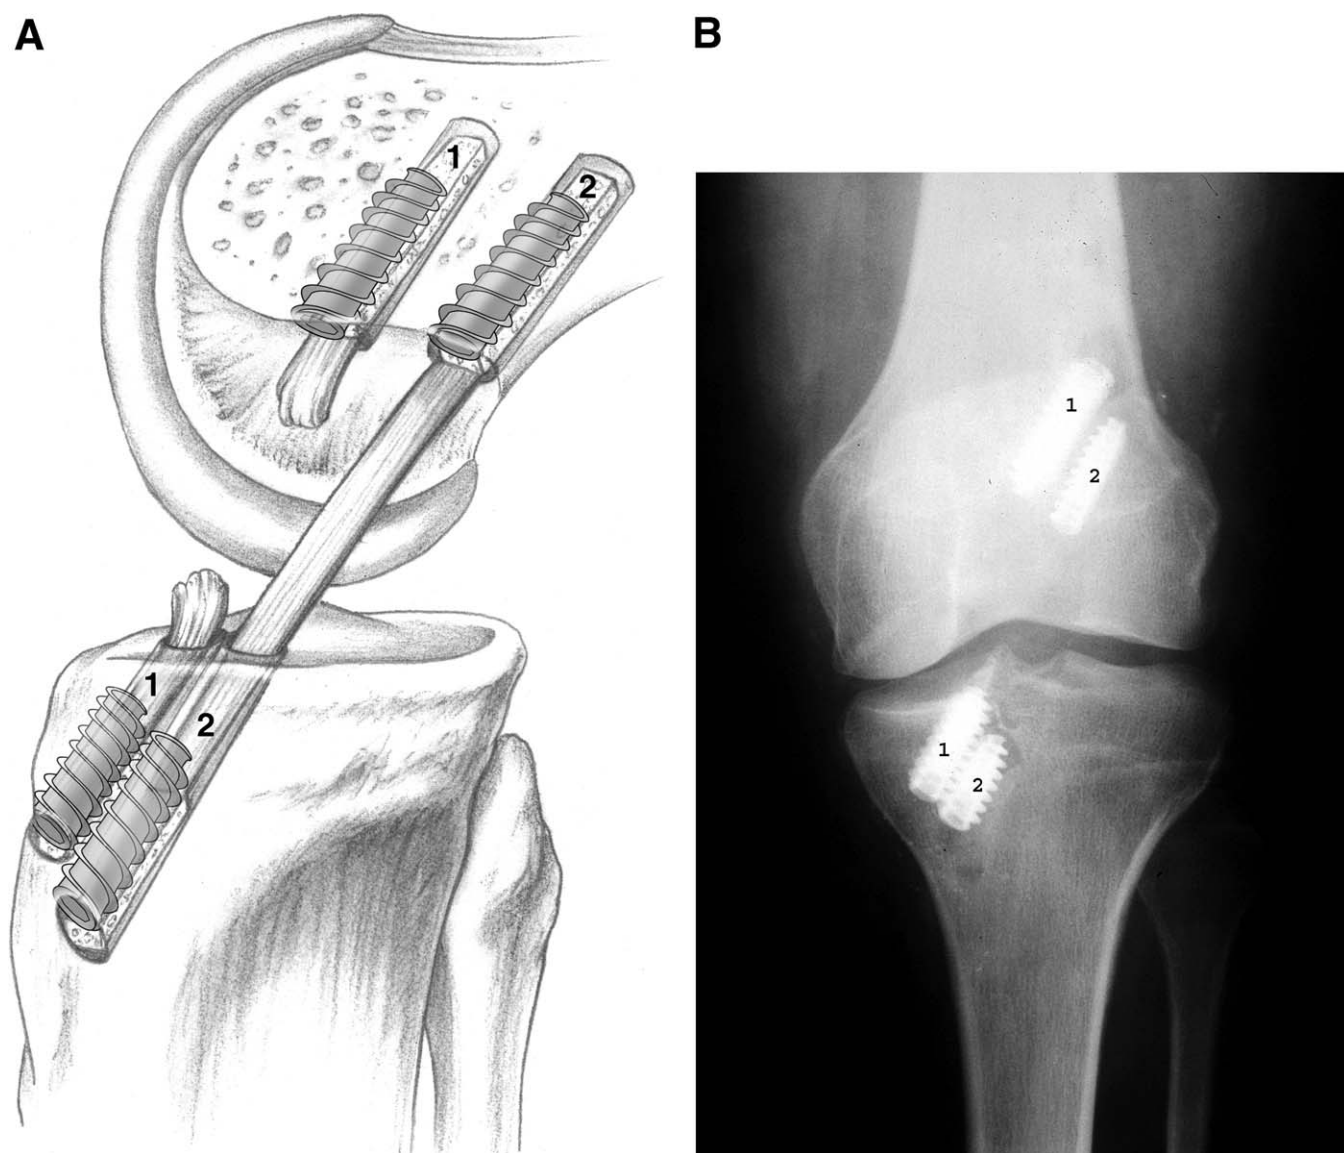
(A) Pre-existing nonanatomic femoral tunnel that was by-passed by a new, anatomically positioned tunnel. The orientation of the initial tunnel might necessitate screw removal during tunnel reaming and subsequent reinsertion. (Reproduced with permission from Bach et al.¹⁰ © 2002 American Academy of Orthopaedic Surgeons.) (B) Radiograph showing by-passing of a pre-existing malpositioned tunnel without hardware removal. (1) Index hardware; (2) revision hardware.
